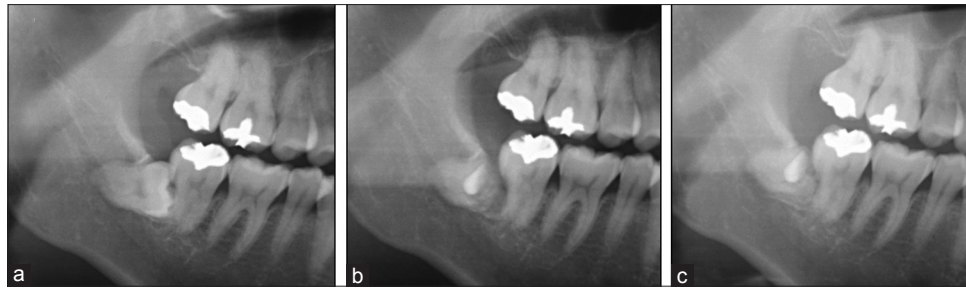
(a) Preoperative radiography. (b) Radiograph after coronectomy. (c) Radiograph 4 months after coronectomy
